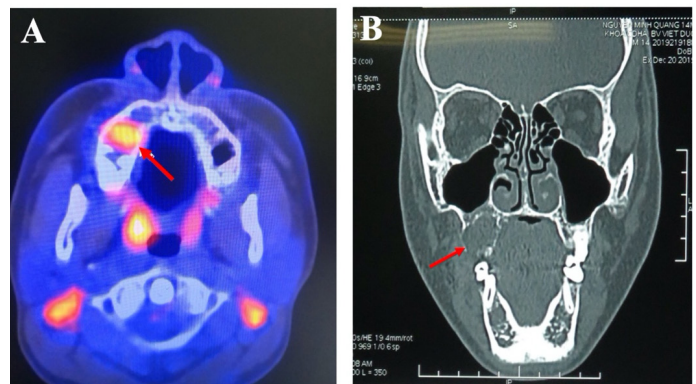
(A) Positron emission tomography/computed tomography (CT) with ¹⁸fluorodeoxyglucose, (B) CT scanner, T1W images show a osteolytic lesion in the right maxilla, intense FDG uptake, hypointense on T1W and non-homogenous gadolinium enhancement (red arrows)
